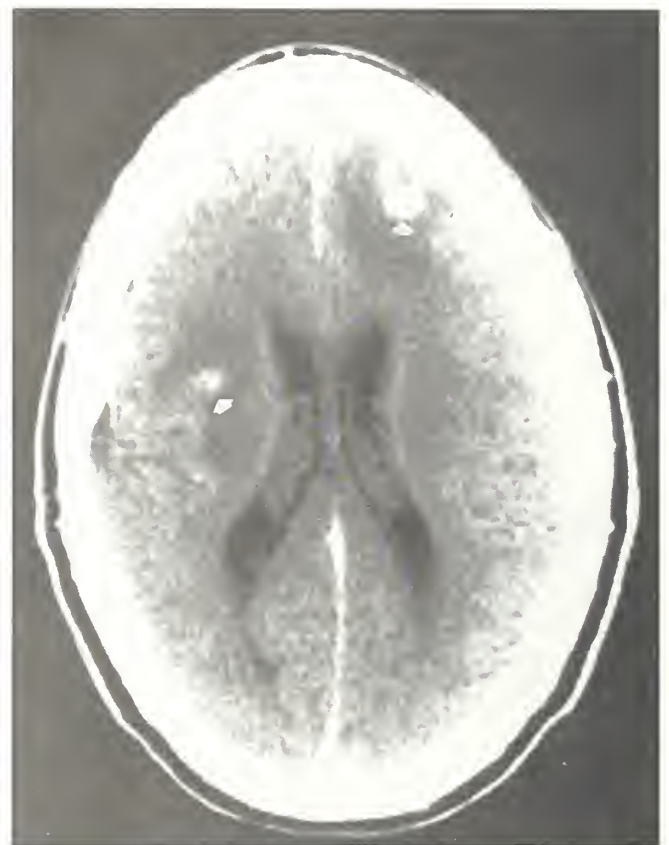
Thirty-one-year-old man with presumed CNS tuberculosis. Head CT with intravenous contrast demonstrating multiple nodular and ring enhancing lesions (arrows).
